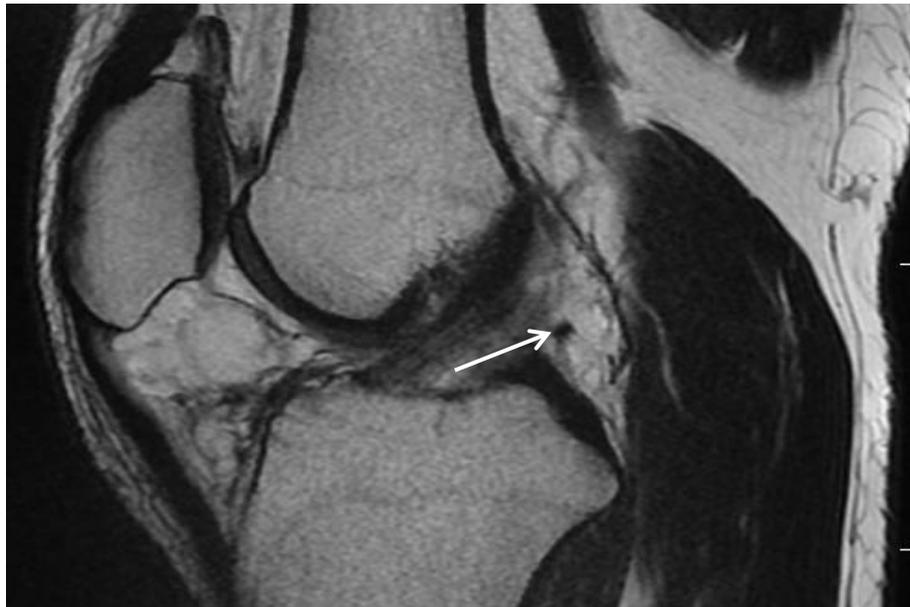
MR image of the knee joint, same patient. Sagittal projection. Anterior cruciate ligament injury. Anterior cruciate ligament thickened, no changes in signal characteristics
